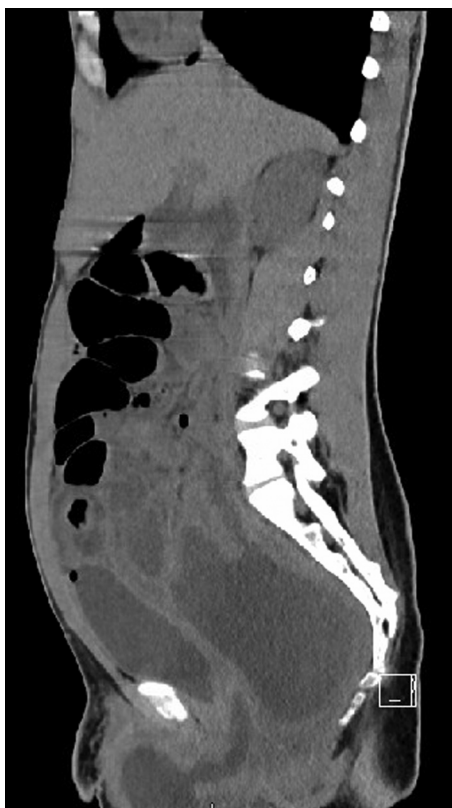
Abdominal CT at admission: pelvic abscess (sagittal view). CT= computed tomography.
